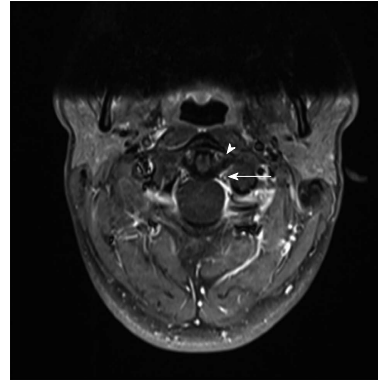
Follow-up magnetic resonance imaging. High resolution contrast-enhanced 3T magnetic resonance imaging, fat-saturated gradient echo sequence. After physical therapy stabilization. Note the clear contrast enhancement in the periligamentous venous plexus (arrow head) and the symmetric space evaluation (white arrow).
